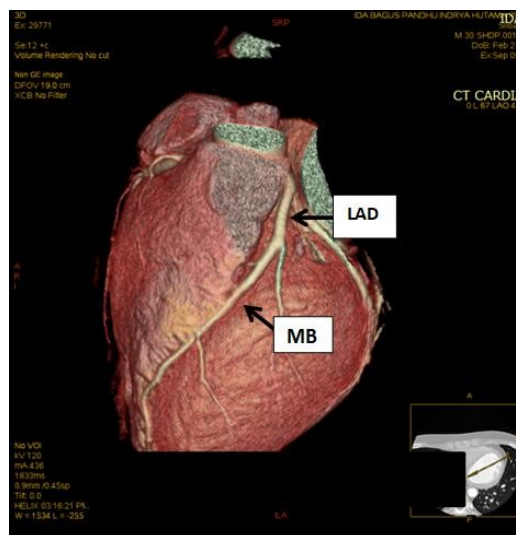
Coronary computed tomography angiography (CCTA) shows myocardial bridging (MB) at mid LAD coronary artery
